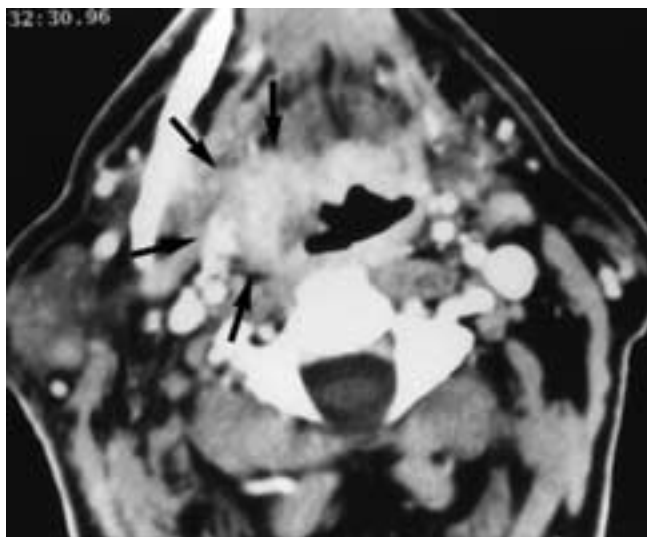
Axial contrast-enhanced CT scan shows the nonspecific CT appearance of an adenoid cystic carcinoma arising from the tongue base (*arrows*).
